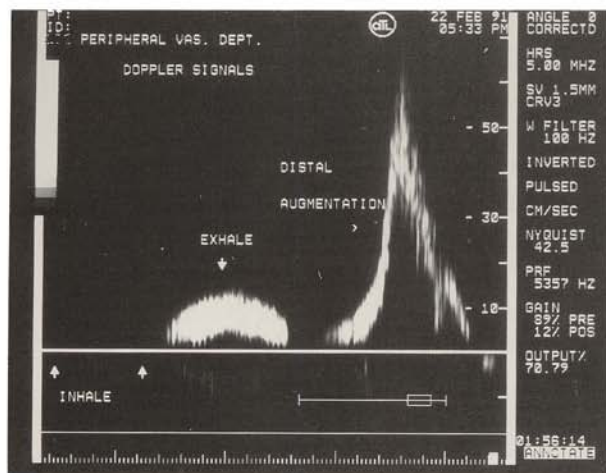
A dramatic increase in forward venous flow as a result of manual compression below the site of Doppler examination suggests that the segment of vein between the point of compression and the sample site is patent. The normal finding in this example suggests patency between the point of calf compression and the sample site in the femoral vein.
